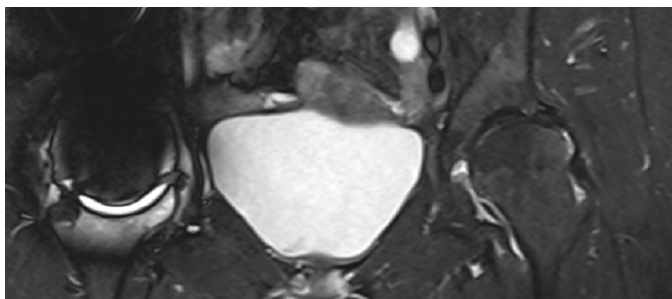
MRI of the left hip showing effusion and a widespread focal area of enhanced marrow signal intensity in the femur bone
